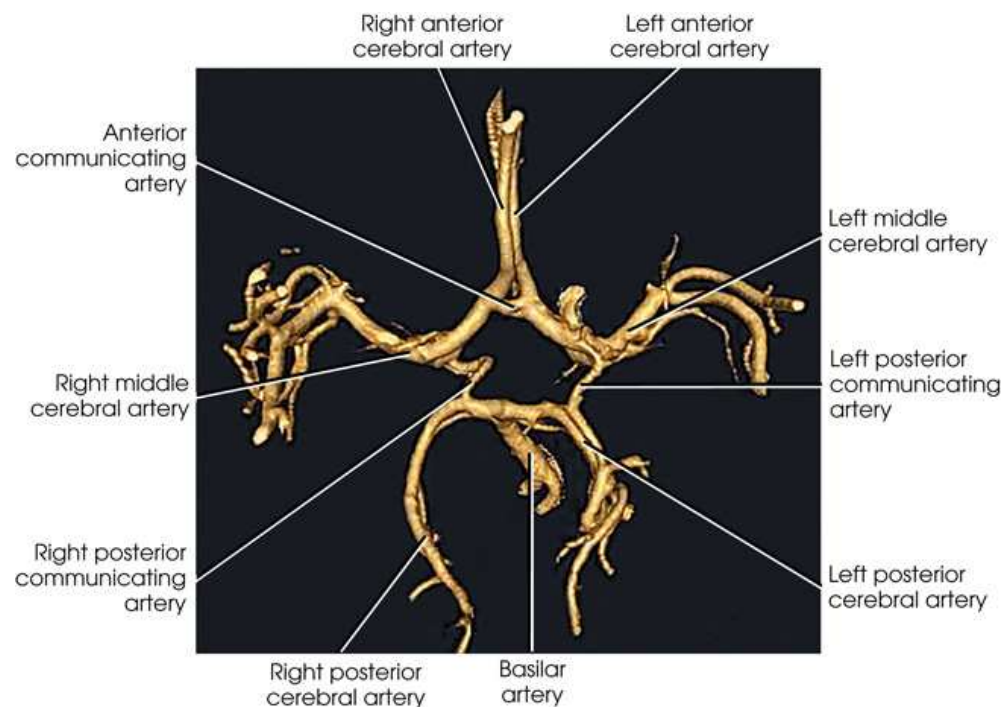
Color CT angiography of circle of Willis.
